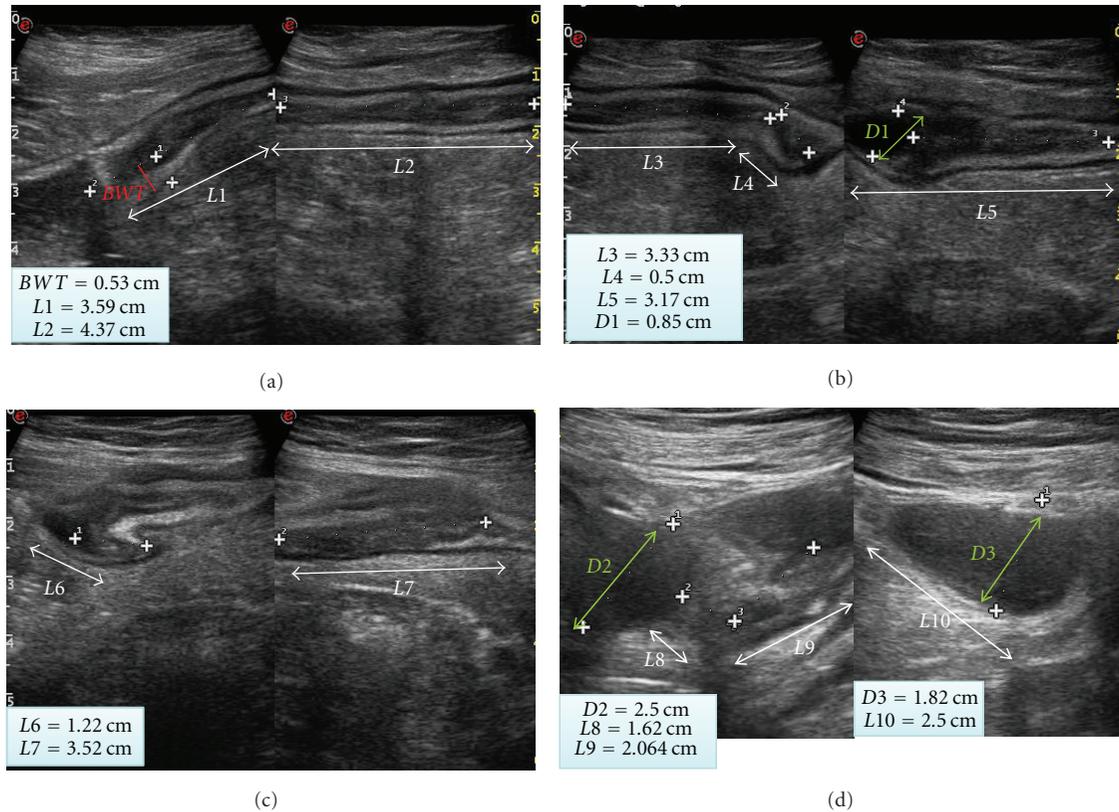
Small intestine contrast ultrasonography in a 20-year-old female with Crohn's disease. In each panel ((a)–(d)) white arrows indicate disease extent of the terminal ileum. The cumulative extent of the sonographic Crohn's disease lesion was 26 cm. In (a), on the left side, red arrow indicates bowel wall thickness (5.3 mm) of the terminal ileum and in (b) (on the left side) and (d) green (both right and left sides) arrows indicate lumen diameter (ranging from 8 to 22 mm) at level of the terminal ileum.
